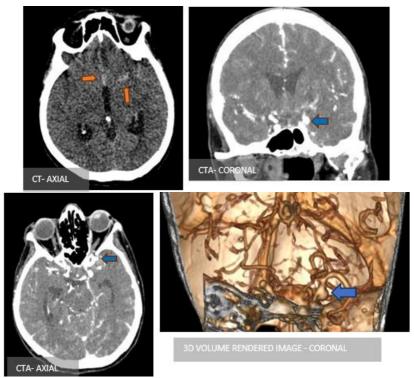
CT cerebral angiogram shows, Acute sub arachnoid hemorrhage (orange arrows) in the left sylvian fissure, anterior inter hemispheric fissure, peri mesencephalic and pre pontine cisterns on the left in the non- contrast images. A contrast filled out pouching arising from proximal supraclinoid segment of the left ICA which is consistent with an saccular aneurysm (blue arrows).
